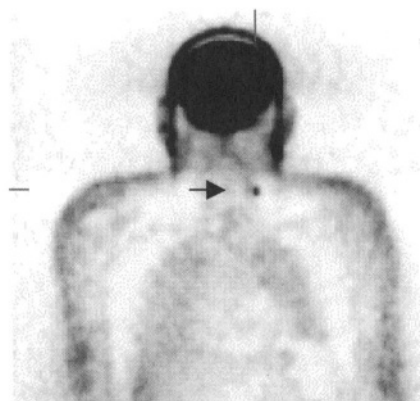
50-year-old patient with papillary thyroid carcinoma, negative posttherapeutic ^{131}I -WBS 10 days after a treatment dose of 5550 MBq, thyroglobulin 25 ng/ml. FDG PET coronal slice showing a small lesion in the right neck (arrow) that proved to be a small metastasis of papillary thyroid cancer.
